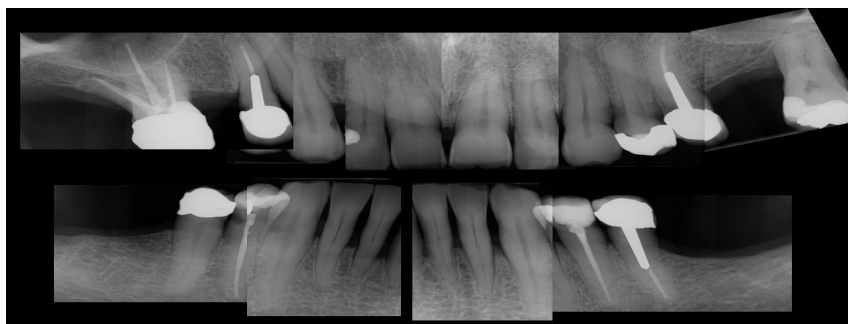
Intraoral X-ray examinations, mounted. Periodontal reevaluation, cariologic and endodontic diagnostics – S. J. - * 05/19/1958 2019 (FMDC +6 month)
